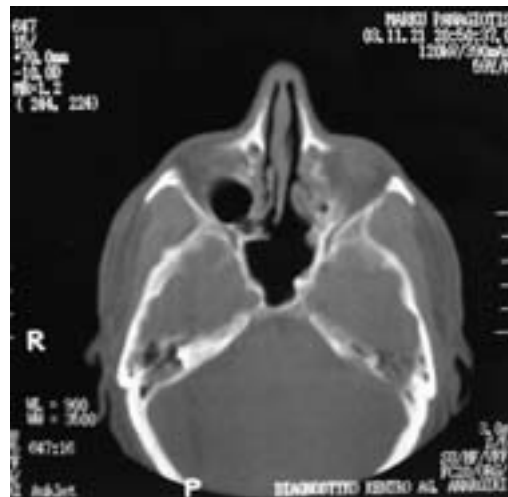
Axial CT view showing the sphenoid sinus of patient case No 3 12 months postoperatively. The sinus appears recurrence free.
